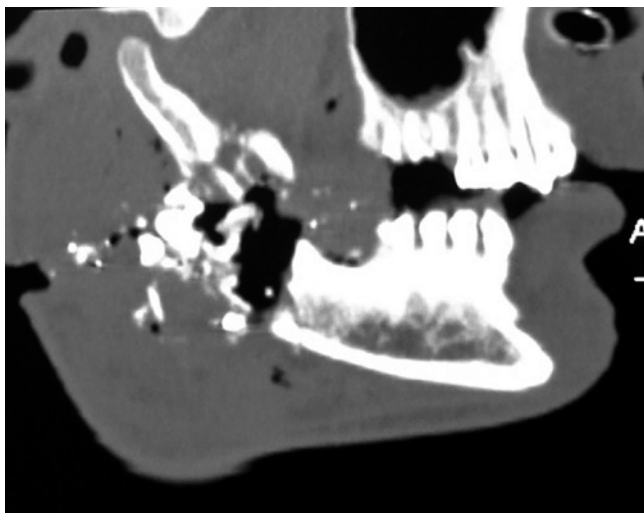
CT scan showing extent of internal bony disruption
